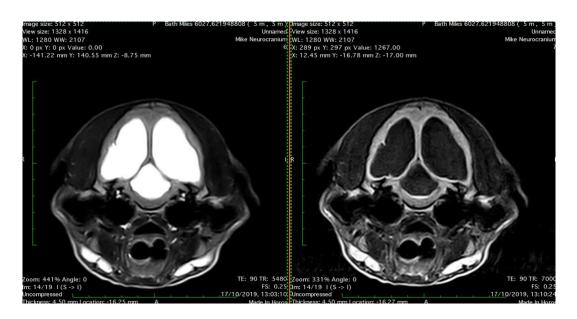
Trv T2W (left) and FLAIR (right) cranial medulla oblongata
